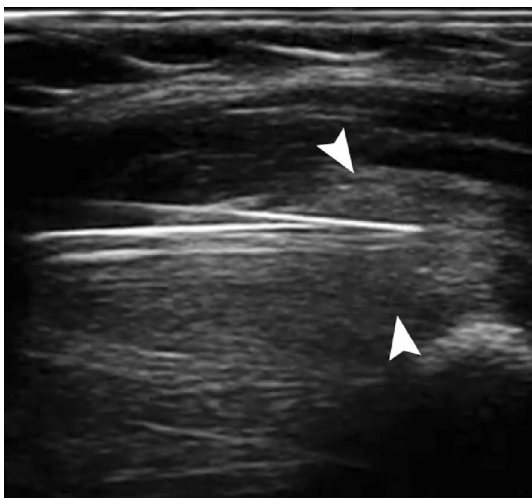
Ultrasound image of the “two needles” technique; two 14G needles are seen facing each other inside a soft 13 mm calcification (white arrowheads)
